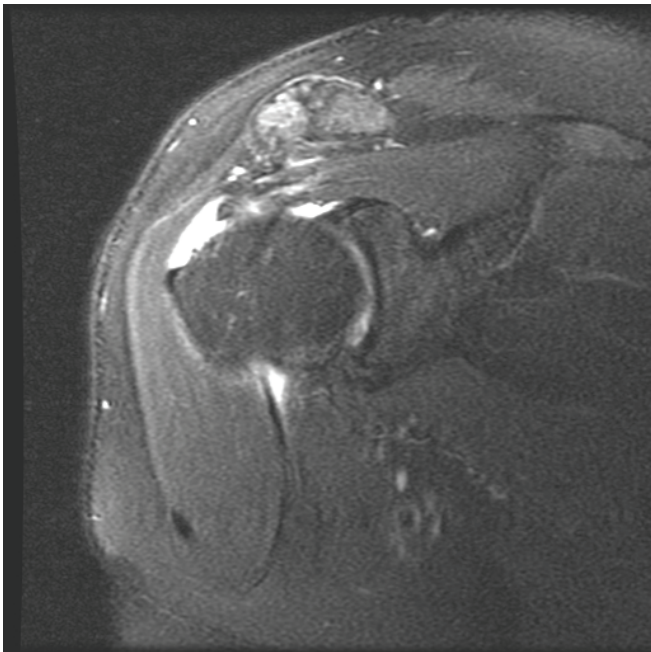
Coronal magnetic resonance image of a right shoulder demonstrating a full-thickness rotator cuff tear.
